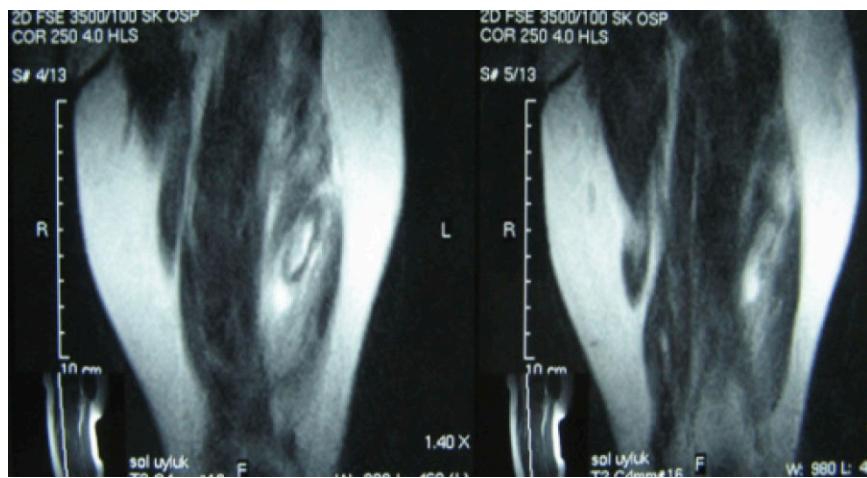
An MRI scan shows injury to the muscle, indicating the need for additional diagnostic testing. (credit: Aydemir G, Cakmak S, Aydinoz S/NIH, CC BY 2.0)
